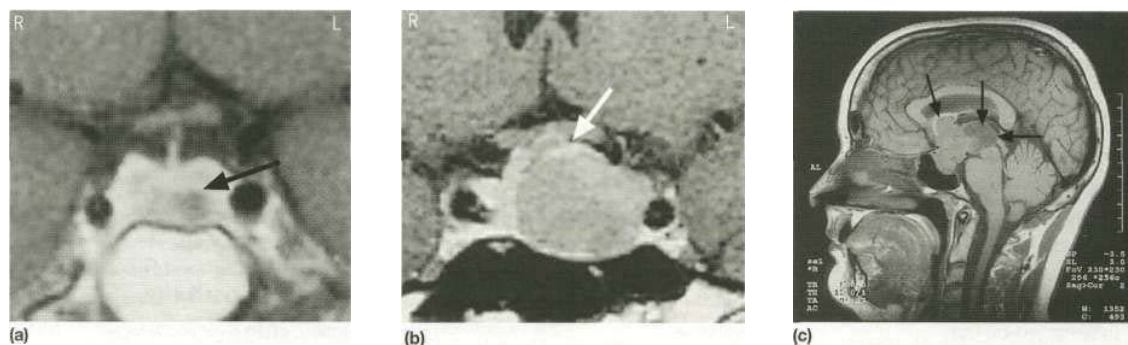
(a) Coronal MRI of pituitary, showing a left-sided lucent intrasellar microadenoma (arrowed). The pituitary stalk is deviated slightly to the right, (b) Coronal MRI of pituitary, showing macroadenoma with moderate suprasellar extension, and lateral extension compressing left cavernous sinus. The top of the adenoma is compressing the optic chiasm (arrowed). (c) Sagittal MRI of head, showing a pituitary macroadenoma with massive suprasellar extension (arrows).
